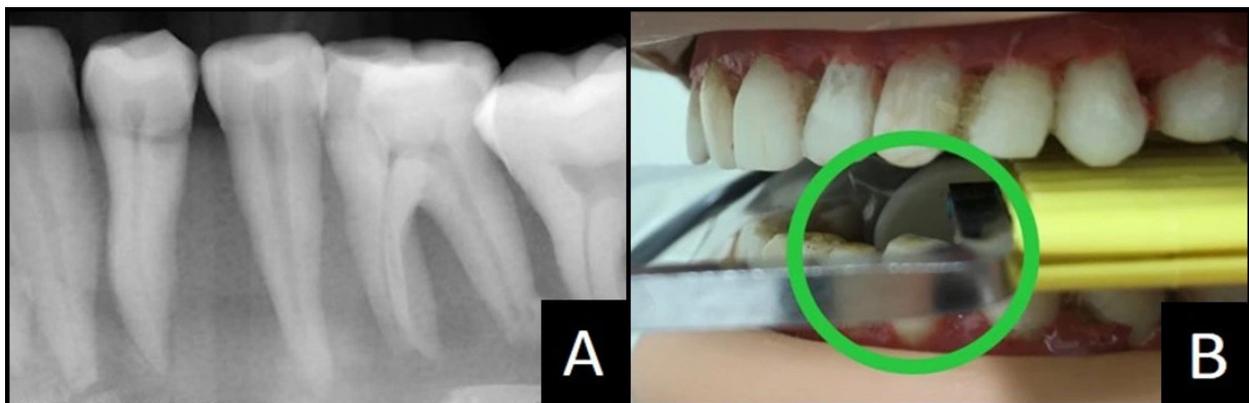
Premolar Periapical
